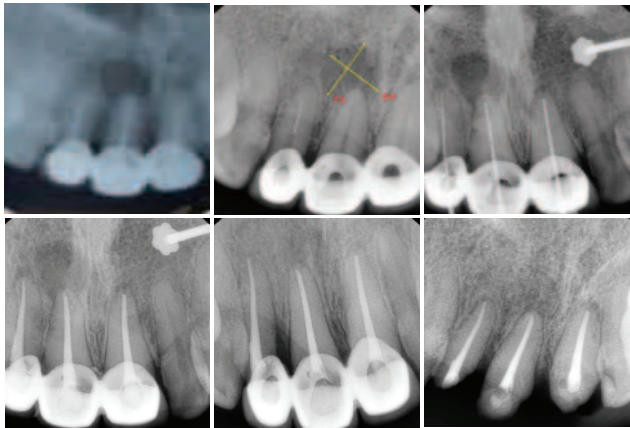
A - F. Re-root canal treatment of failed endodontically treated teeth # 11, 12, and 21, follow-ups, and final restorations. A, Pre-operative intraoral periapical view showing a large oval-shaped radiolucency around the apex of tooth # 11 and a small radiolucency around the apex of tooth # 21; B, Establishing the access to the root canals and removal of the gutta percha obturating material from # 11, 12, and 21. The periapical lesion around the apex of tooth # 11 is measured at 7.5 x 6.8 mm; C, Working length determination; D, Obturation with Gutta Percha; E, 13 and half-months-follow-up showing bone regeneration and complete periapical healing; F, Removal of the faulty indirect restorations for restoration correction.
